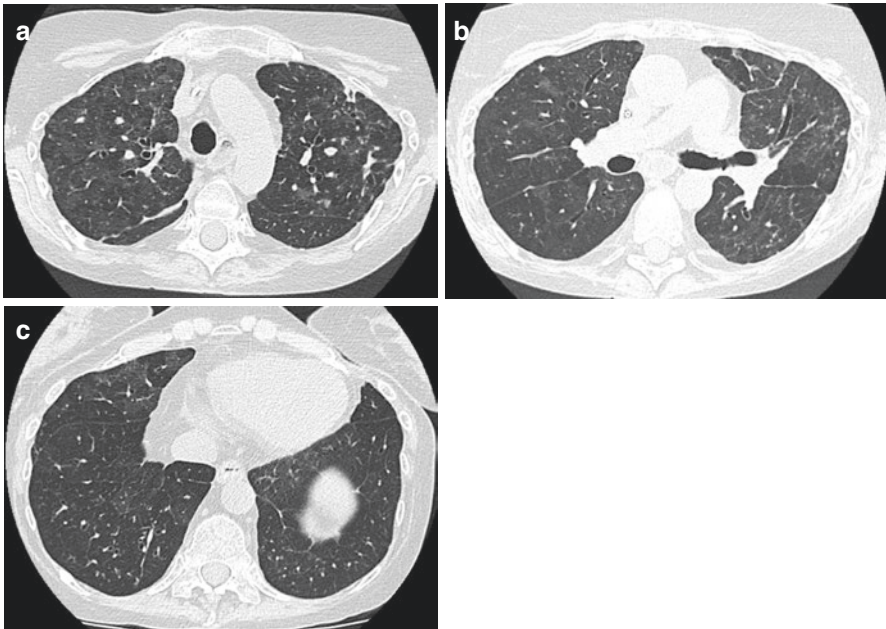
(a–c) Serial axial CT images (a–c) were performed in a 62-year-old male patient who is status post DLT with evidence of bronchiectasis, bronchial wall thickening, and mosaic attenuation with peripheral areas of diminished pulmonary arterial vascularity, most compatible with bronchiolitis obliterans
